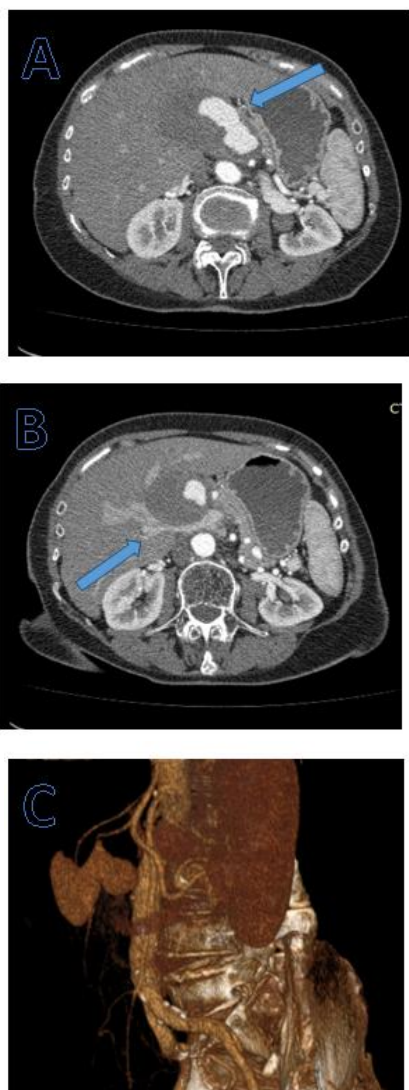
Computed tomography CT findings. A) and B) Enhanced axial abdominal CT scans show large, irregular pseudoaneurysm of common hepatic artery with partially thrombosed wall and compression of the portal vein (arrows); C) 3-dimensional VR angiography shows the aneurysm with wide neck arising from vertically oriented CHA
